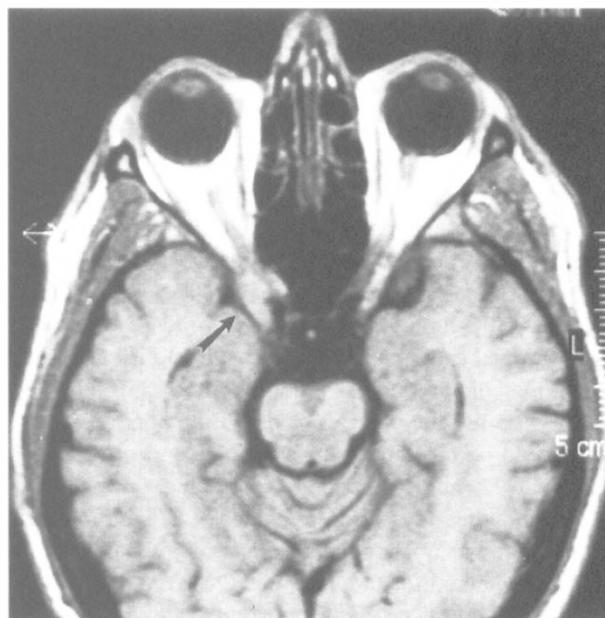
Axial T1-weighted view demonstrating a 2 cm lobulated extra-axial mass (arrow) extending to the right optic foramen with compression of the right optic nerve.
